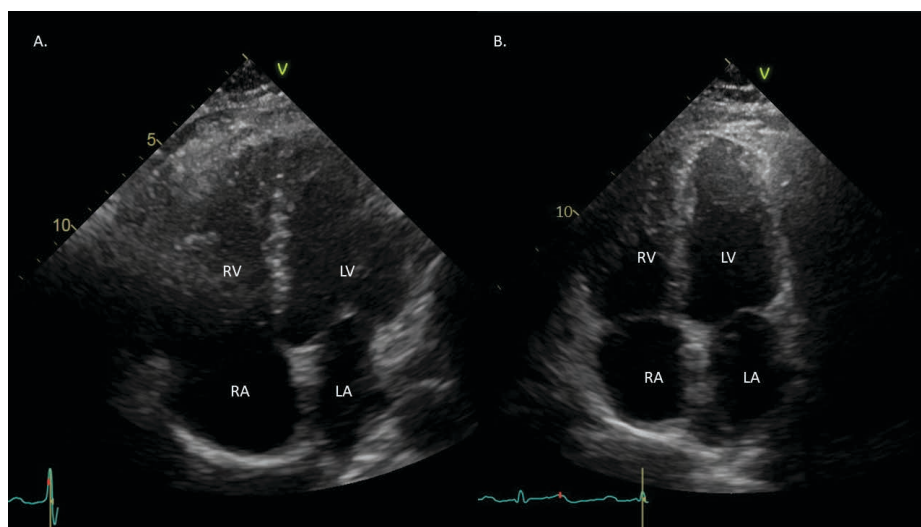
Cardiovascular remodeling after successful BPA. Apical 4-chamber views of transthoracic echocardiograms performed 2 weeks before BPA sessions began (A) and 1 year after sessions completed (B) for the male patient presented in Figures 2 and 3. This patient had 4 total sessions with 9 different lesions treated. Note the decrease in size of the RV and RA afterwards, with concomitant increase in size of the LA. There was also notable improvement in right ventricular systolic function seen. BPA indicates balloon pulmonary angioplasty; LA, left atrium; LV, left ventricle; RA, right atrium; LV, left ventricle.
